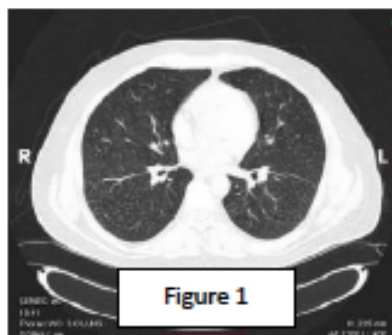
A chest CT revealed a miliary reticulonodular pattern presumed to be due to bronchiolitis related to smoking marijuana. Image from: <https://journals.sagepub.com/doi/pdf/10.1177/107327481602300311>
